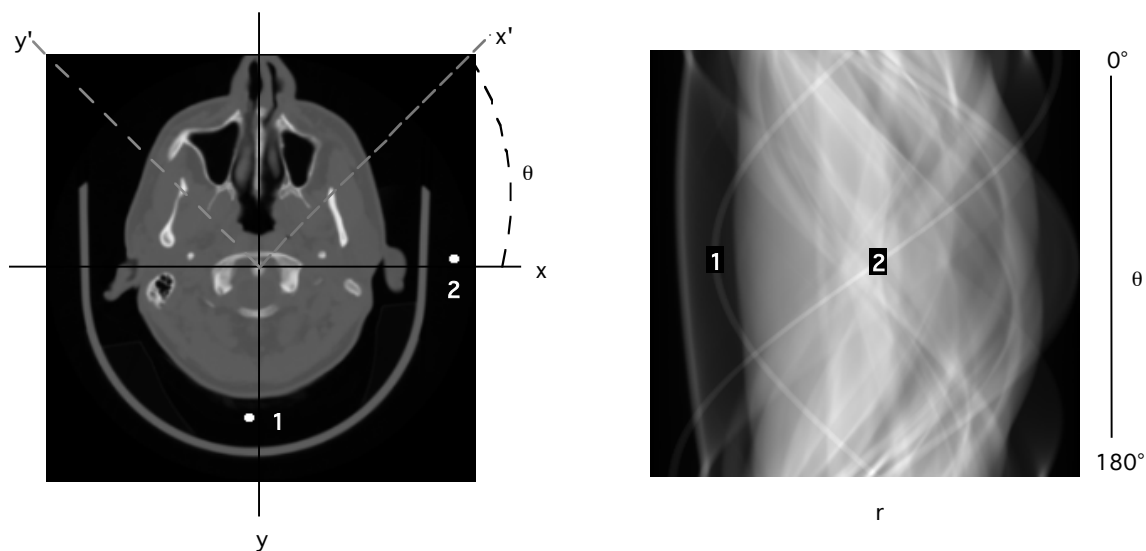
A CT image (a) and its projections $p_\theta(r)$ (b) presented as an image called a sinogram.
